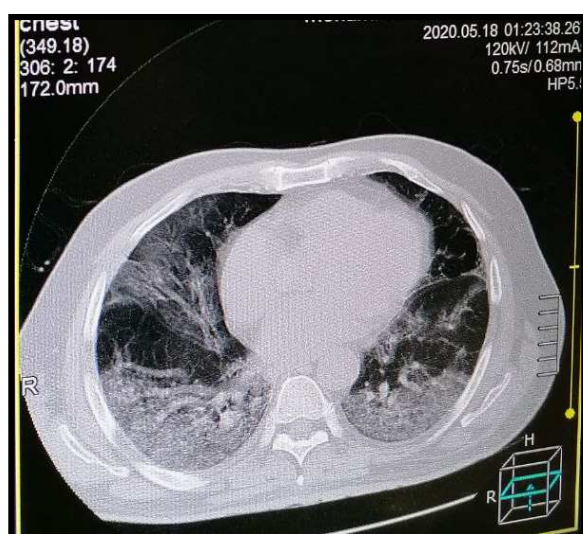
Noncontrast chest HRCT images in a 55-year-old woman with severe COVID-19.
